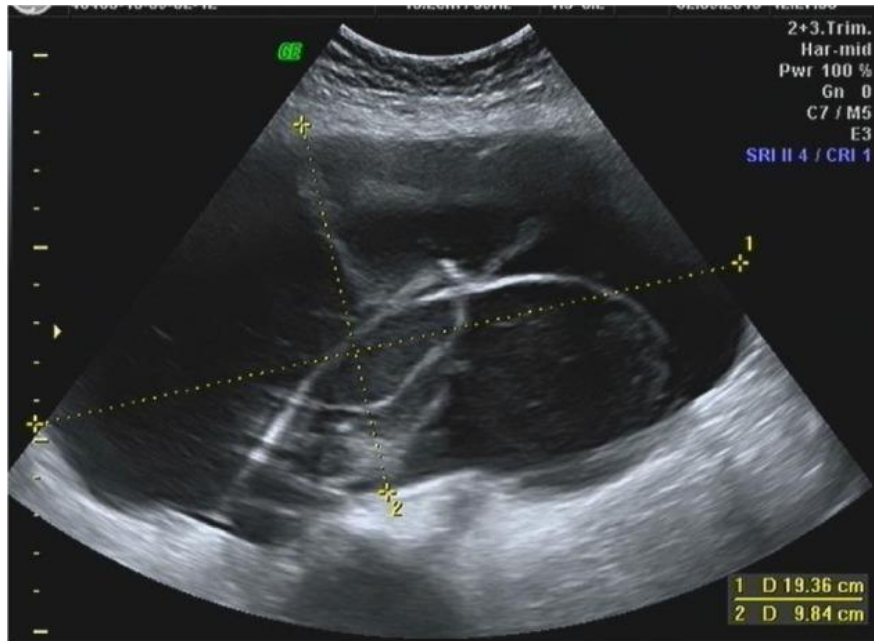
Transabdominal ultrasound scan in a 41-year-old woman.
